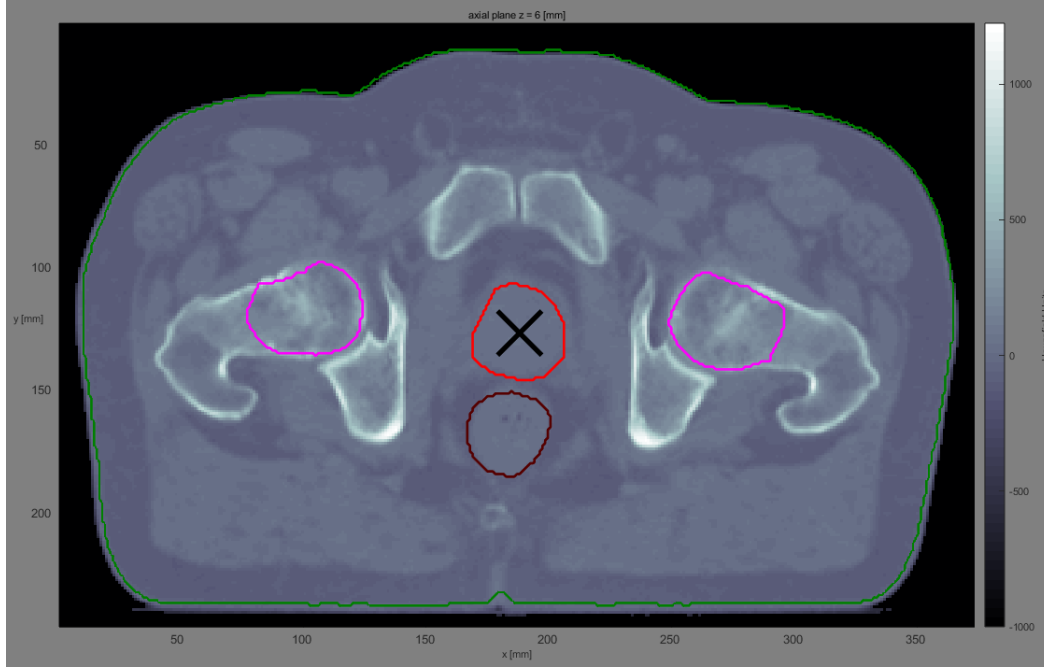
Given prostate patient CT dataset imported into matRad and visualized using the matRad GUI. A candidate CTV, representing the prostate, is highlighted (red) as well as possible OARs, representing both femoral heads and the rectum (pink and dark red).
